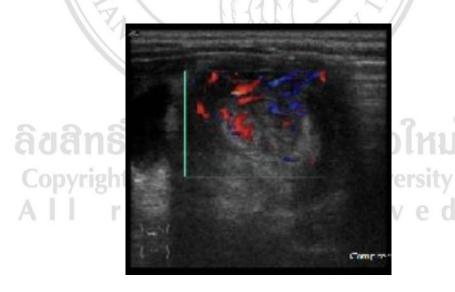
Ultrasonography with Doppler signal shows abundant flow in intussusception.
